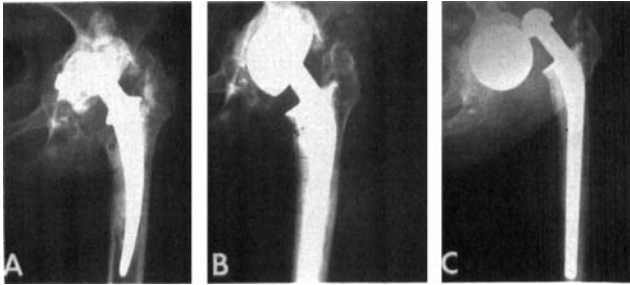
A 67-year-old woman. (A) Aseptic loosening of acetabular and femoral components, left total hip arthroplasty. (B) Immediate postoperative radiograph after bipolar revision and acetabular bone grafting. (C) Disassembly of bipolar head 10 days postoperatively because of implant defect. The patient ultimately had a good result, but the initial technique was considered a failure.
